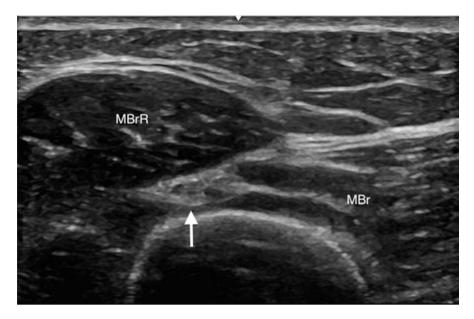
Radiographic imaging showing a conventional percutaneous electrode over radial nerve
